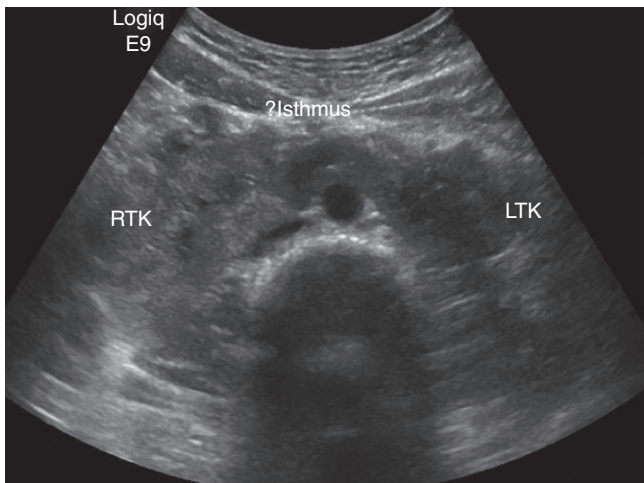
Ultrasound image in a different patient demonstrates a horseshoe kidney, with renal parenchyma connecting the inferior poles of bilateral kidneys, anterior to the aorta. (RTK=right kidney and LTK=left kidney).
